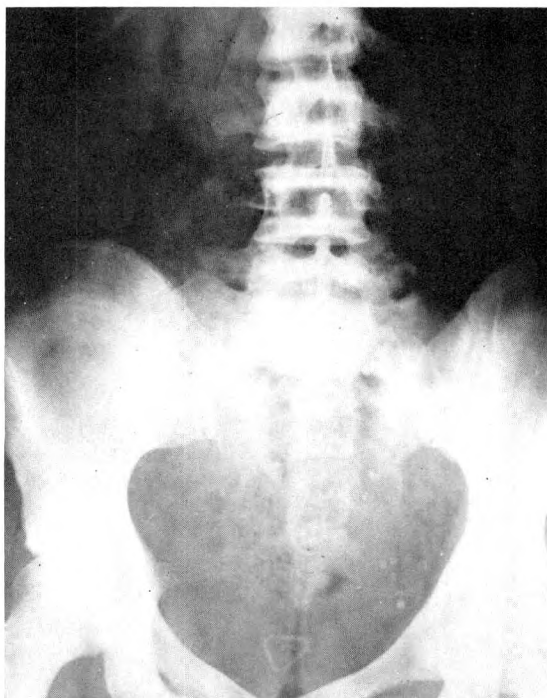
Roentgenogram of the pelvis demonstrates laminated ring-like densities of the iliac bones. These alternating lines of increased and decreased density point to the fact that the disease process is subject to remissions and exacerbations.
